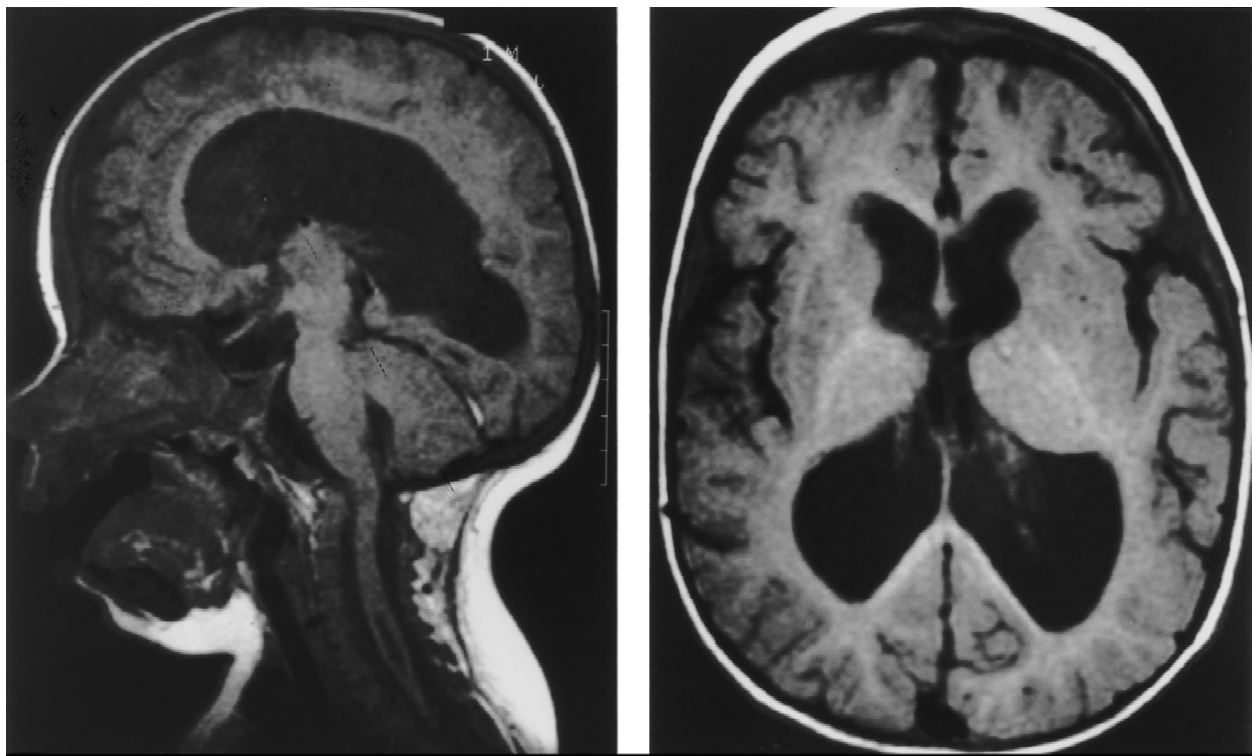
Sagittal and axial T1-weighted MR images of the brain of patient 1 show ventriculomegaly, widened sulci and enlarged extra-axial subarachnoid spaces consistent with communicating hydrocephalus. A cervical syrinx is present. There is no empty sella.
